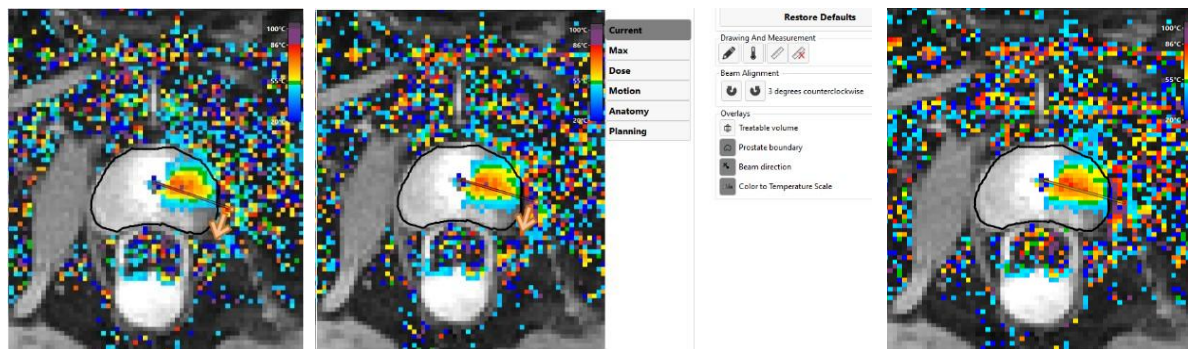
Misaligned ultrasound heating and UA beam angle
